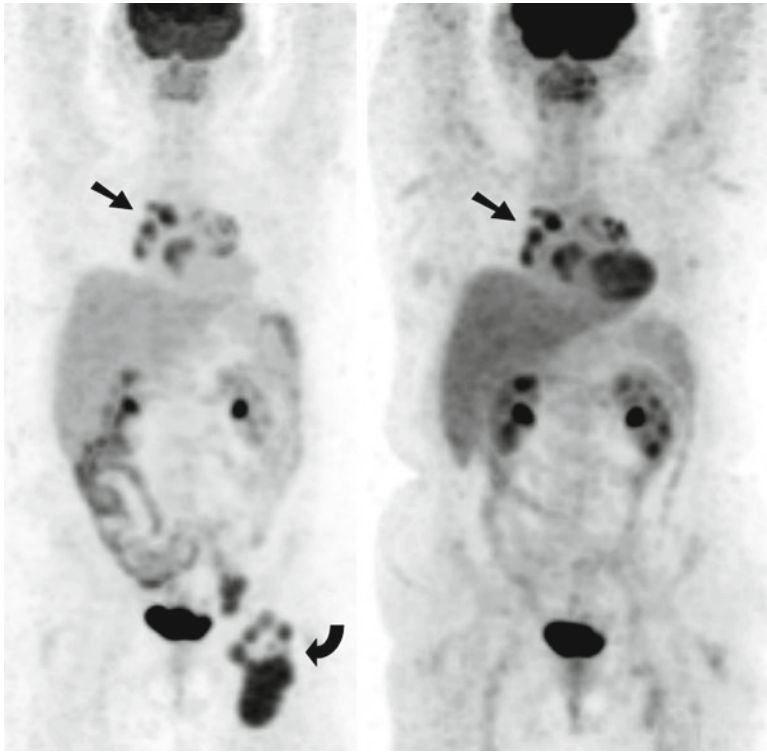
Sarcoidosis as a mimic of malignancy. A 56-year-old woman with newly diagnosed diffuse large B-cell non-Hodgkin's lymphoma (NHL) underwent a staging FDG PET scan (*Left*). There was intense FDG uptake within multiple lymph nodes in the left groin (*curved arrow*) at the sites of biopsy proven NHL, as well as moderate to intense foci at the pulmonary hila and mediastinum bilaterally which were more marked on the right side (*arrow*). Following completion of chemotherapy, a repeat FDG PET (*Right*) was undertaken which demonstrated marked metabolic response at the sites of lymphoma in the left groin; however, the uptake
